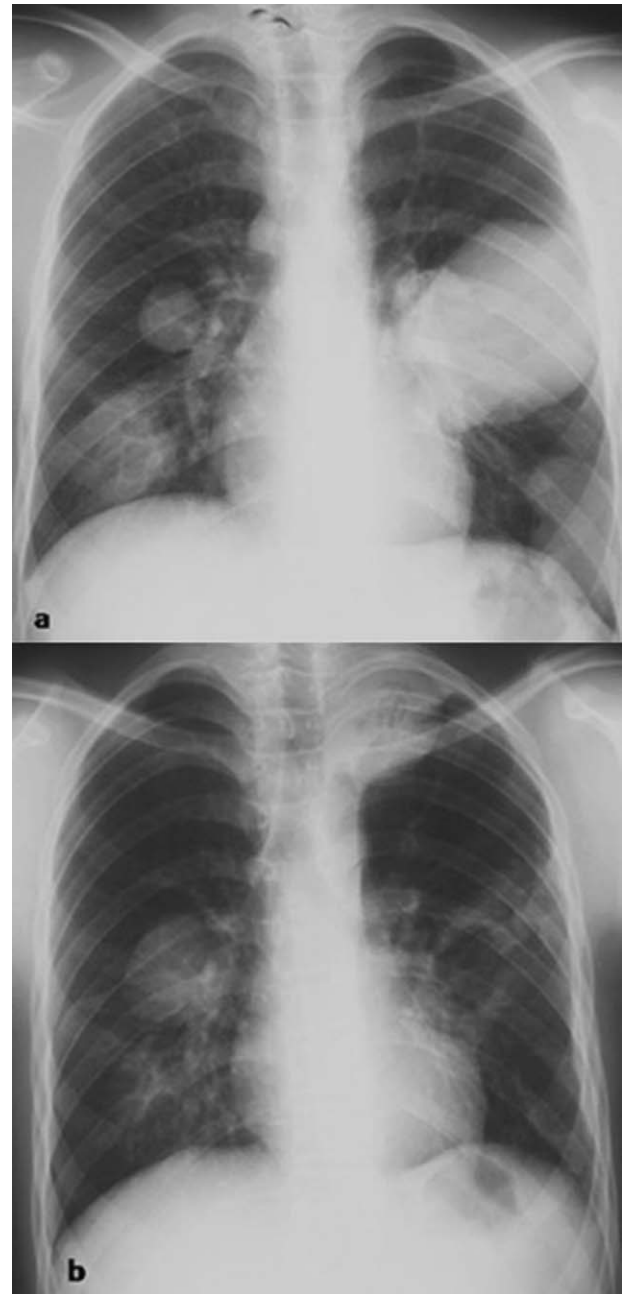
(a) Chest radiograph before chest surgery shows bilateral echinococcal cyst. (b) Chest radiograph realized 45 days after chest surgery (resection of a left echinococcal cyst) shows a left residual cavity with an ipsilateral superior pleural mass with gas bubbles. One of the remaining right pulmonary echinococcal cysts is complicated by rupture into the bronchi.
